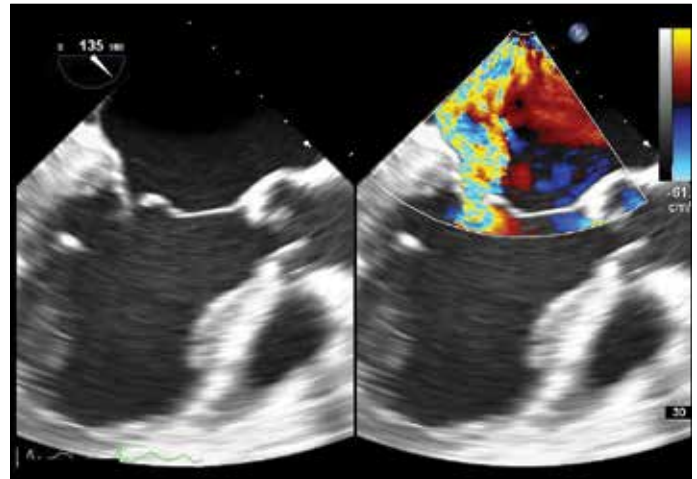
Transesophageal echocardiography demonstrates a posteriorly directed eccentric jet of severe mitral regurgitation from the middle scallops of both mitral leaflets (A2 and P2 segments) with flail anterior mitral valve leaflet in long-axis view
